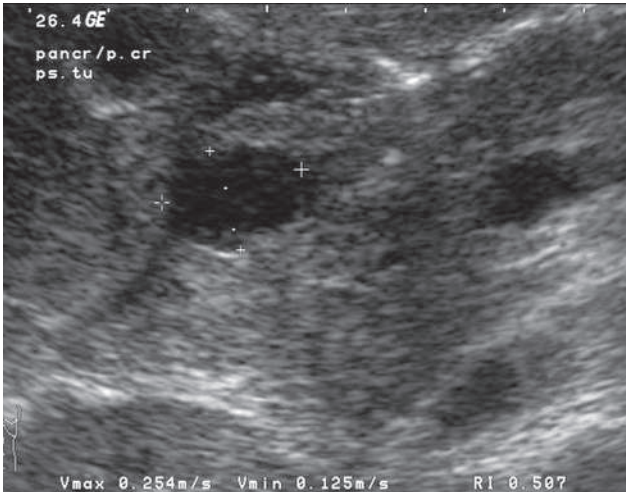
Pseudoaneurysm of the gastroduodenal artery (“grey scale” ultrasonographic appearance).
